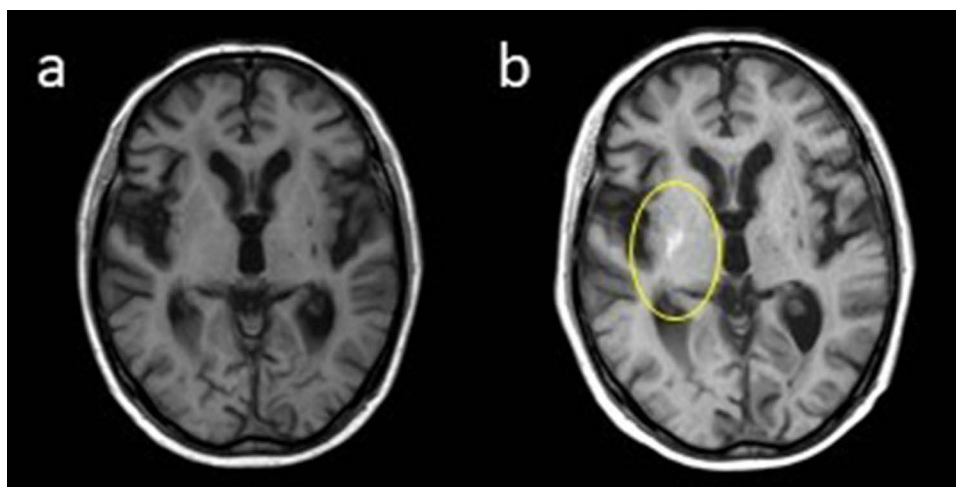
Magnetic resonance imaging (MRI) on the day of examination (a) and 14 days later (b).
